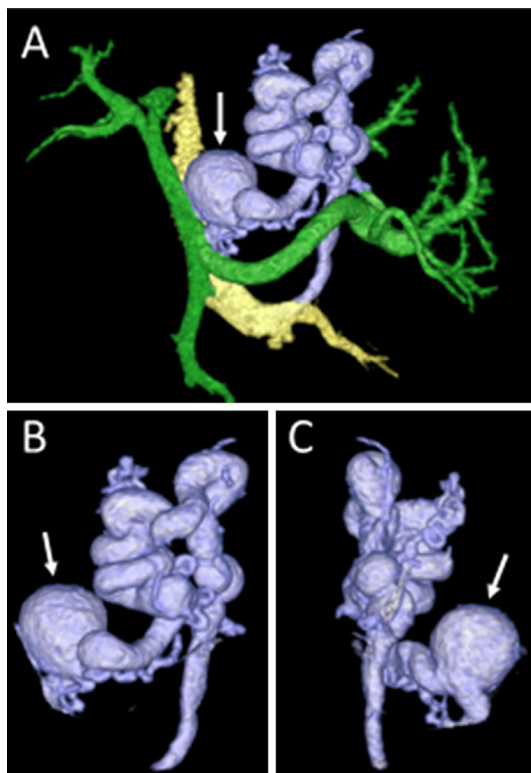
Multidetector computed tomography images showing the location of a left gastric vein aneurysm. A) Relative location of a left gastric vein aneurysm (arrow) in the portal venous system. Yellow indicates the inferior vena cava and left renal vein. Green indicates the main portal vein, splenic vein and superior mesenteric vein. Purple indicates the left gastric vein aneurysm (arrow) and gastrorenal shunt. B) Ventral side of the left gastric vein aneurysm (arrow) and gastrorenal shunt. C) Dorsal side of the left gastric vein aneurysm (arrow) and gastrorenal shunt.
